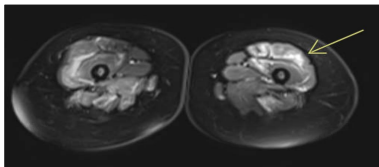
MRI of thighs. T2 weighted image. Arrow indicates bright signal showing myositis (area amenable to biopsy).
